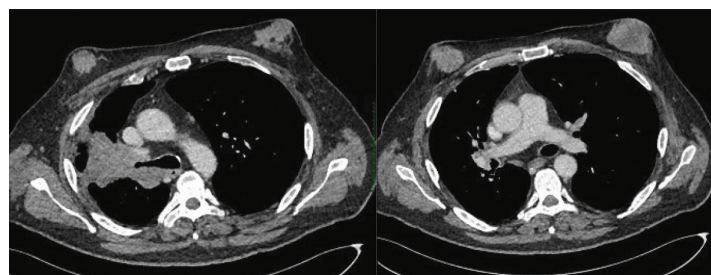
Thoraco-abdominal CT scan injected into the parenchymal window: left upper lobar mass stenosing the right lobar bronchus and “mass” type breast tissue development, bilaterally.
